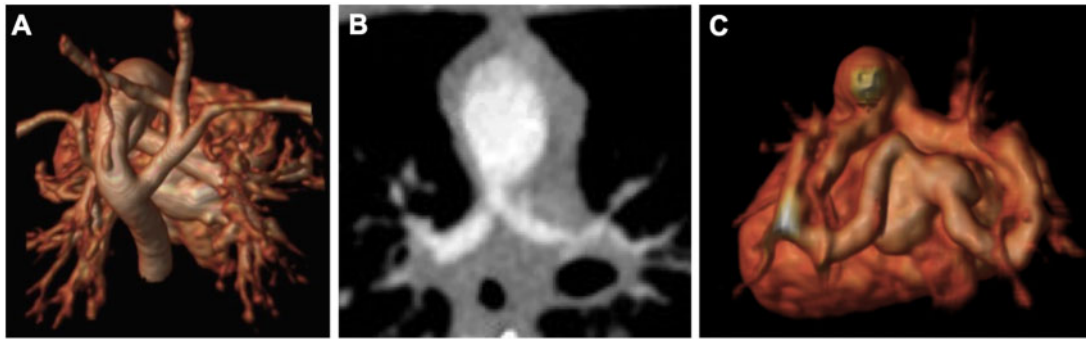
Further preoperative computed tomographic images. Right aortic arch with aberrant right subclavian artery (A), hypoplastic branch pulmonary arteries (B) and abnormal morphology of the pulmonary veins (C).
